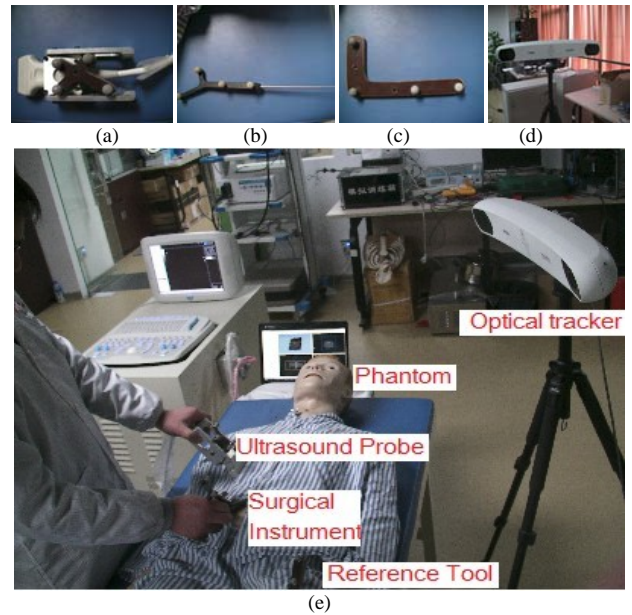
Coordinate system of our system. (a) Ultrasound probe with optical markers and probe coordinate system. (b) Optical tool used as surgical instrument in our experiment and attached with optical markers and its instrument coordinate system. (c) Reference tool and world coordinate system. (d) The Polaris optical tracking system and optical tracker system. (e) All coordinate systems and their functions in our navigation system.
